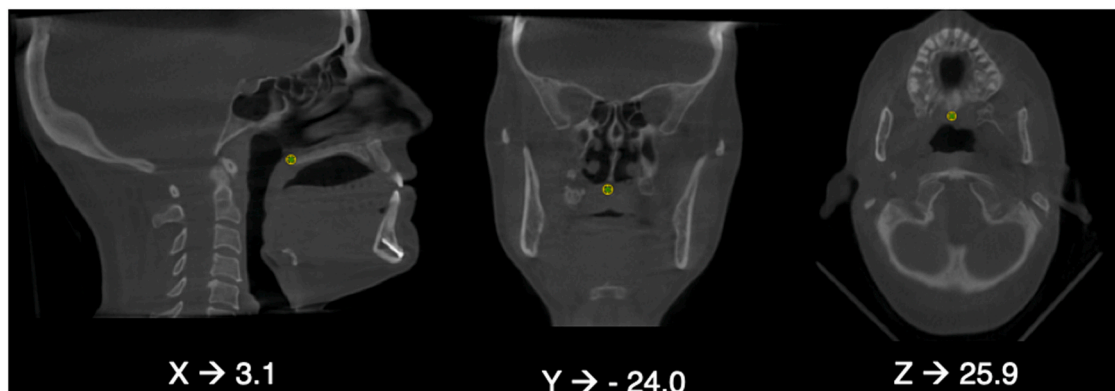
Example of three-dimensional evaluation of the posterior nasal spine (PNS) landmark positioning on CBCT using Dolphin software: X, sagittal view; Y, coronal view; Z, axial view.
